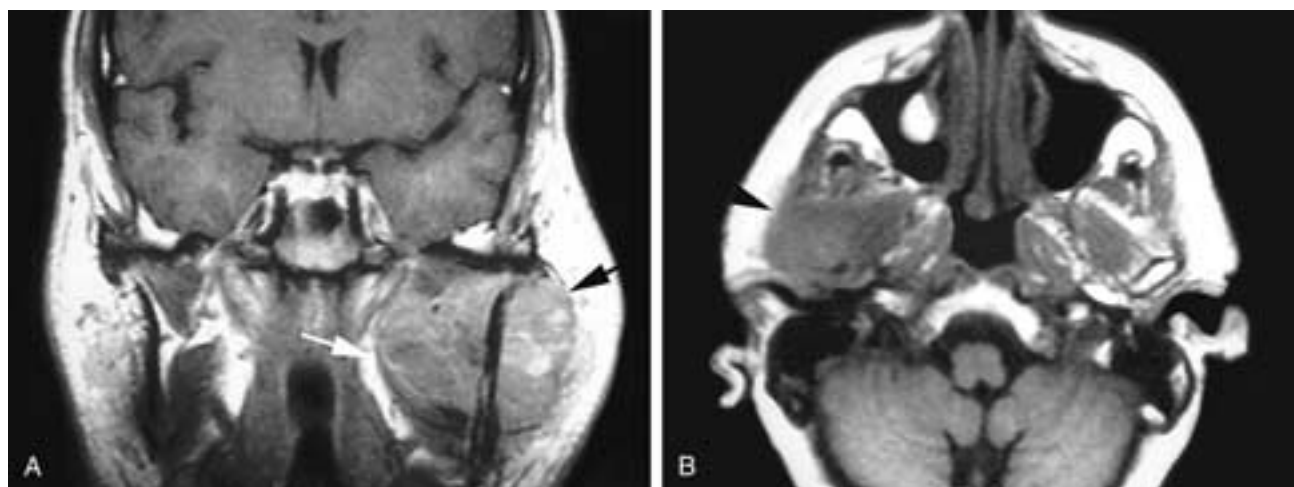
Coronal T1-weighted MR image (A) of a patient with a rhabdomyosarcoma in the left masticator space. Although this is an aggressive tumor, the deep (*white arrow*) and superficial (*black arrow*) leaflets of the SLDCF contain the tumor. In this instance, the integrity of the fascia belies the aggressive nature of the tumor. Axial T1-weighted MR image (B) shows an infiltrating mass in the right masticator space (*arrowhead*). Both the superficial and deep layers of the masticator space fascia have been violated, attesting to the invasive nature of this breast carcinoma metastasis.
